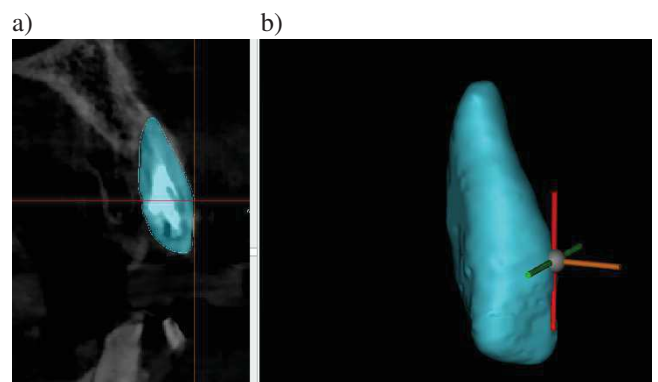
The model tooth which will be replaced with the implant-prosthetic restoration: a) dental panoramic radiograph, b) 3D model
